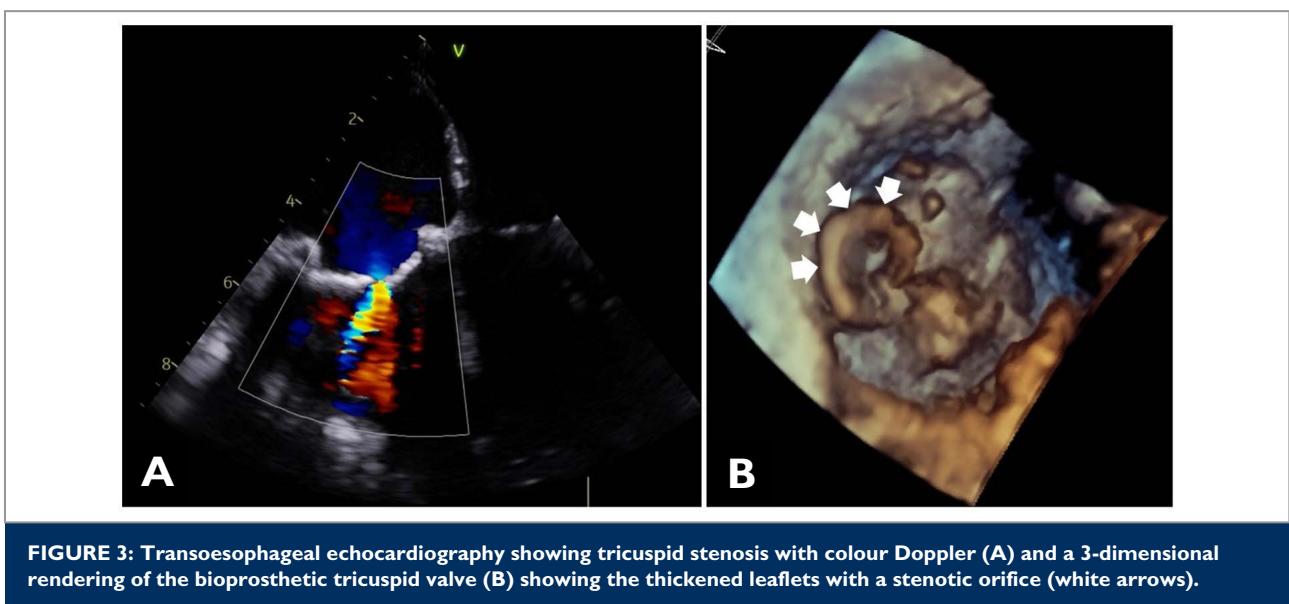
Transoesophageal echocardiography showing tricuspid stenosis with colour Doppler (A) and a 3-dimensional rendering of the bioprosthetic tricuspid valve (B) showing the thickened leaflets with a stenotic orifice (white arrows).
